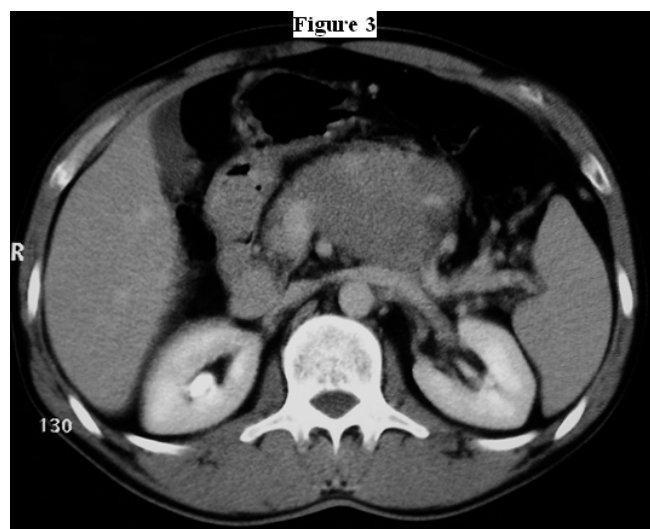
Abdominal CT revealed preaortic soft tissue retroperitoneal mass encasing celiac trunk and proximal branches.
